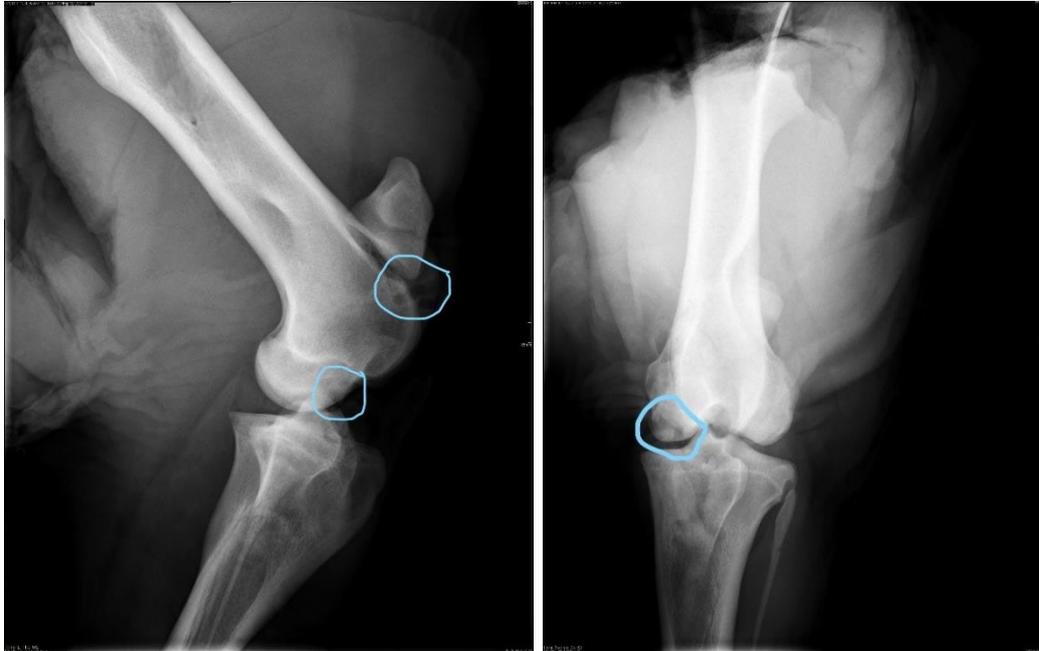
X-rays of pony 27 after the surgery.
